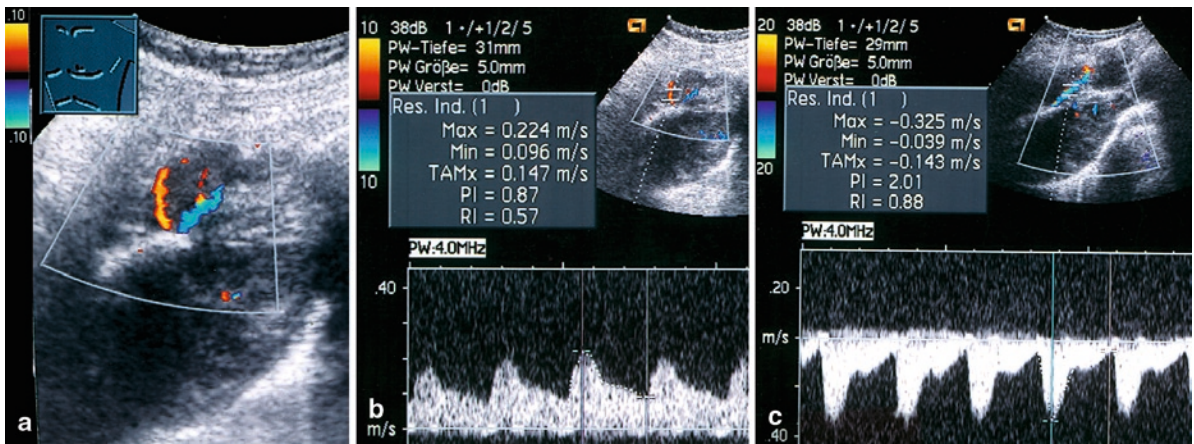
Visualization of a normal intercostal artery in a healthy proband. (a) On B-mode sonography, intercostal transducer guidance demonstrates the intercostal artery. (b) On color-Doppler sonography, the craniocaudal section shows vascular reflexes beneath the ribs. PE pleural effusion. (c) Color-Doppler
